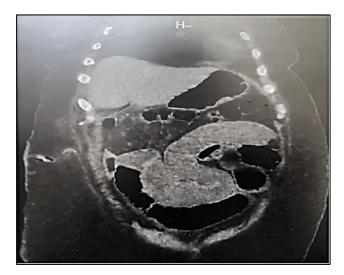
Simple abdominopelvic CT in coronal section showing dilatation of the gastric chamber and intestinal loops as well as a transition zone.
